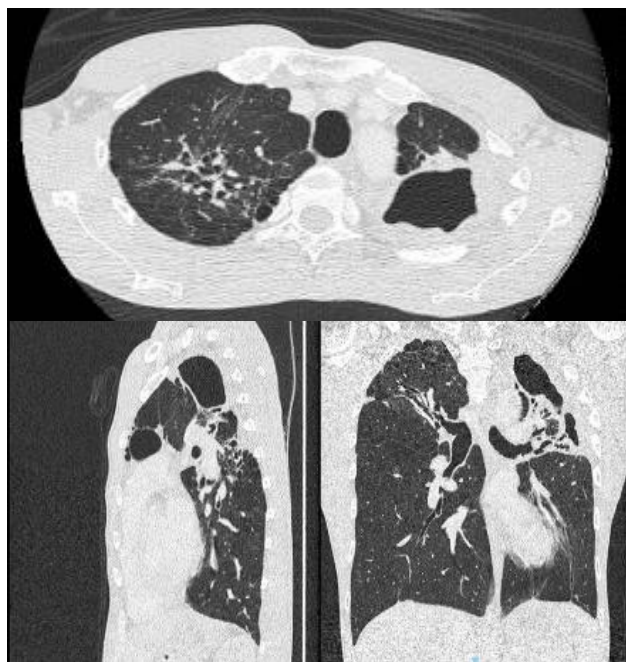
Contrast-enhanced chest CT scan (April 29<sup>th</sup>, 2025)
